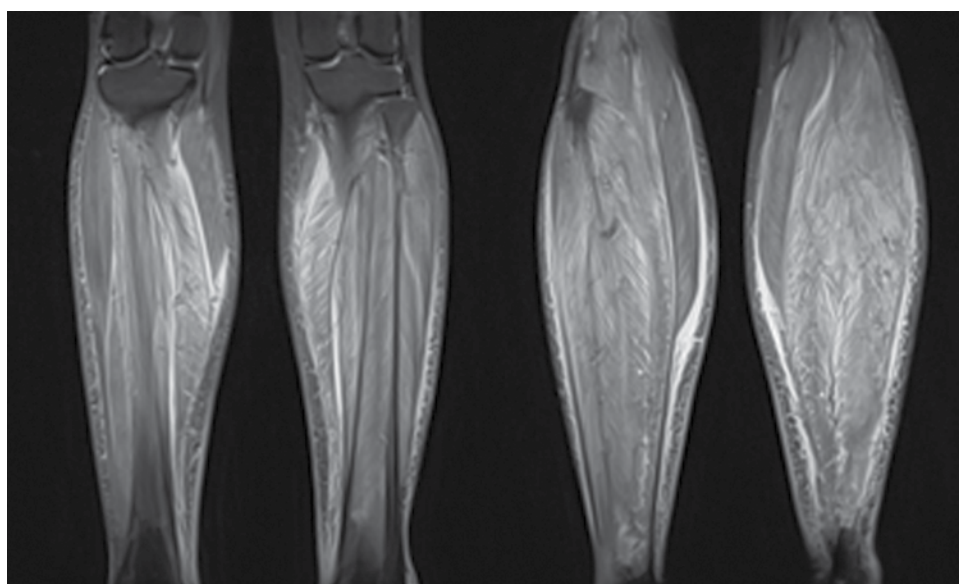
MRI scan showing oedema of the calf muscles.
